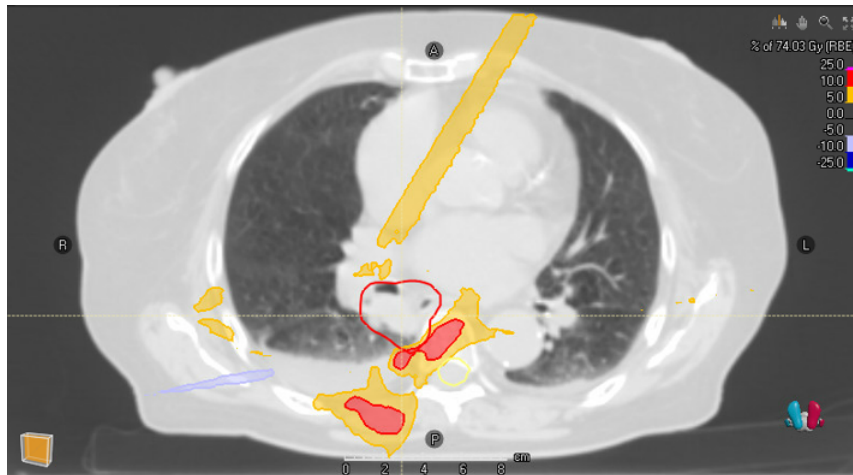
Difference in dose distribution in a single CT 1 slice for patient 12. Dose delivered with IMPT_{3%} is subtracted from dose delivered with IMPT_{4.5%}. The map shows higher dose near the spinal cord (yellow circle) in a IMPT_{4.5%} plan.
